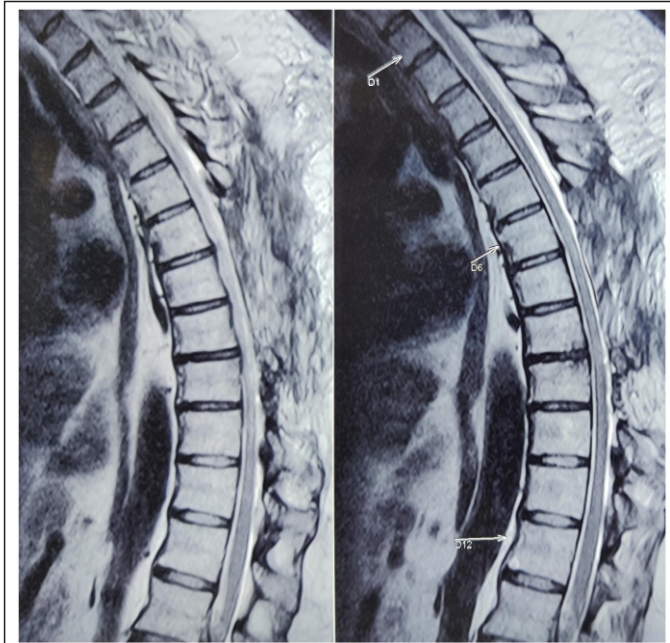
Post-operative MRI at the end of 6 months showing complete cord decompression with no residual abnormal cord signal.
